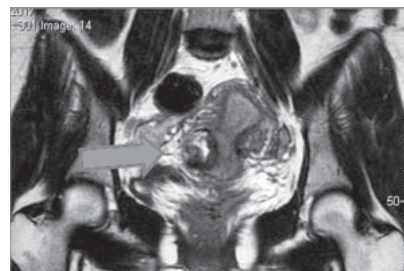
MRI showing Rt. Lateral Ectopic Pregnancy
